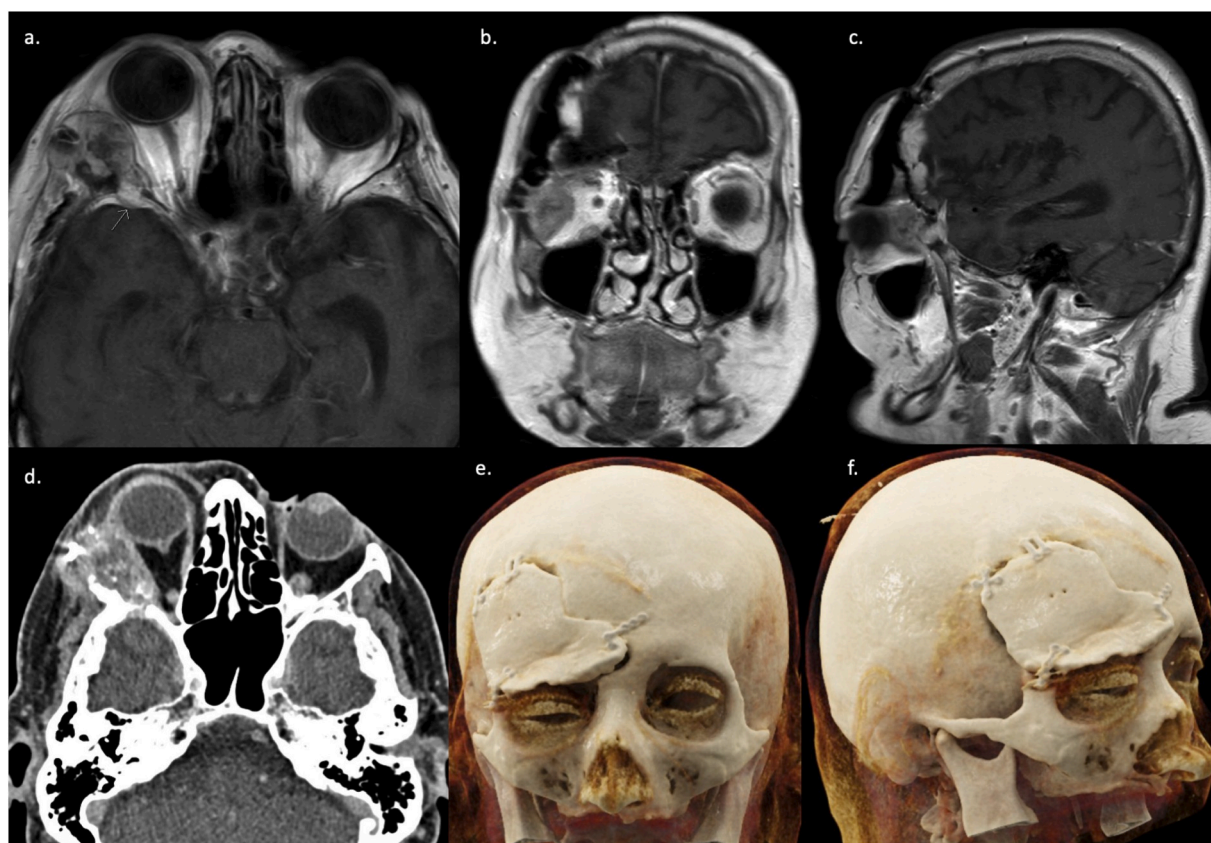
Preoperative imaging. (a–c) MRI imaging (T1-weighted) showing a tumor lesion at the level of the right lateral orbital wall, extending into the lateral part of the orbit. Anterior, reaching to the eyeball, posterior to 4–5mm before the superior orbital fissure. Estimated dimensions: $42 \times 26 \times 30$ mm. (d) CT imaging confirmed the presence of a lobulated tumor recurrence at the right lateral orbital wall with secondary exophthalmia. (e–f) 3D-reconstructed CT images.
